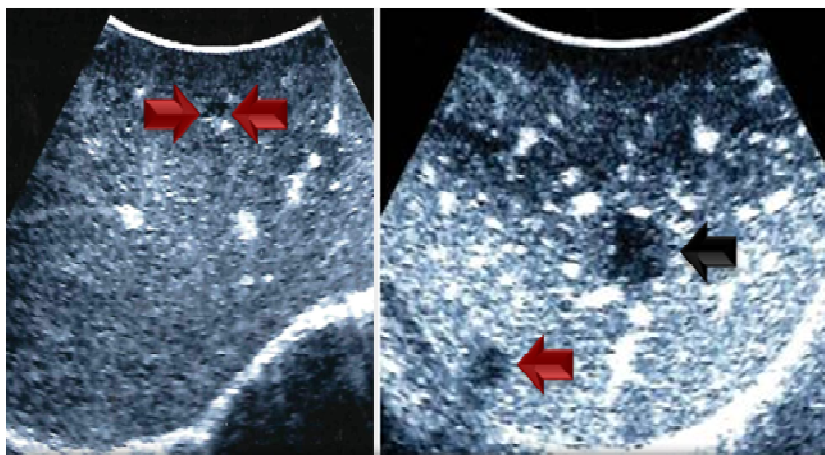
Intra-centimetric metastasis detected by contrast enhanced intraoperative ultrasound (CEIOUS) (colored arrows); the metastasis indicated by the black arrow was previously detected by IOUS
